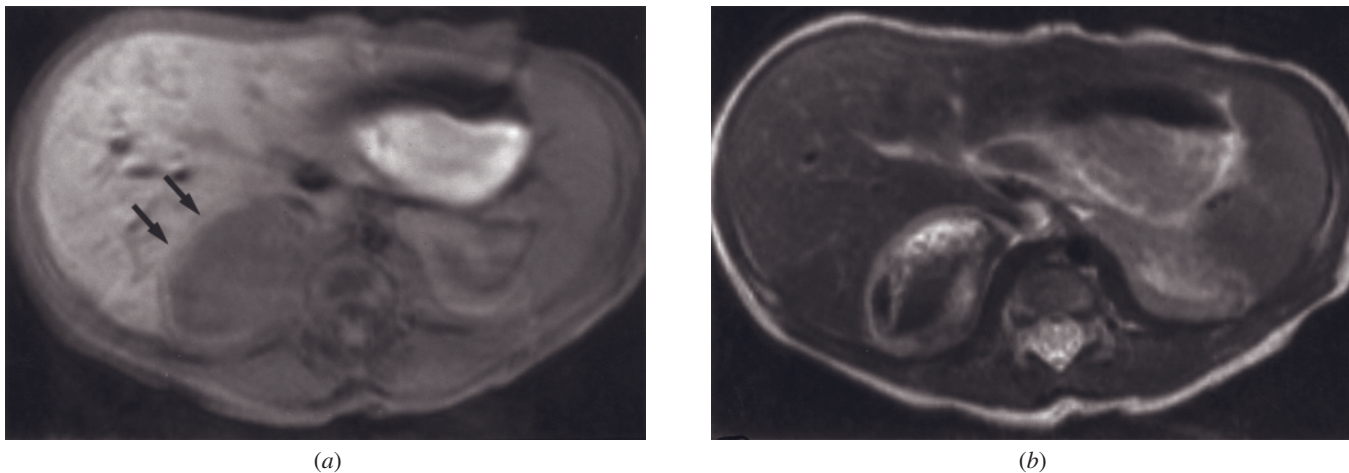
Adrenal hemorrhage. T1-weighted fat suppressed GE (*a*) and T2-weighted echo-train spin-echo (*b*) images in a 4-day-old patient. Mass arising from right adrenal is hypointense with a thin hyperintense rim on T1 (*a*) and heterogeneous on T2 (*b*) with hyper- and hypointense areas representing products of hemorrhage. The peripheral high-signal rim on noncontrast T1-weighted fat-suppressed image (arrows, *a*) represents extracellular methemoglobin and is virtually pathognomonic for a subacute hematoma.
